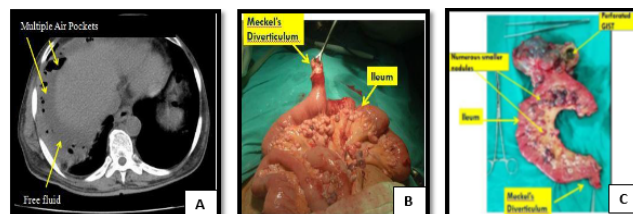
A- Preoperative CT SCAN showing GIST with sign of perforation; B- Intra-operative finding of Meckel's Diverticulitis; C- Intra-operative finding of perforation in larger nodule causing peritonitis.
